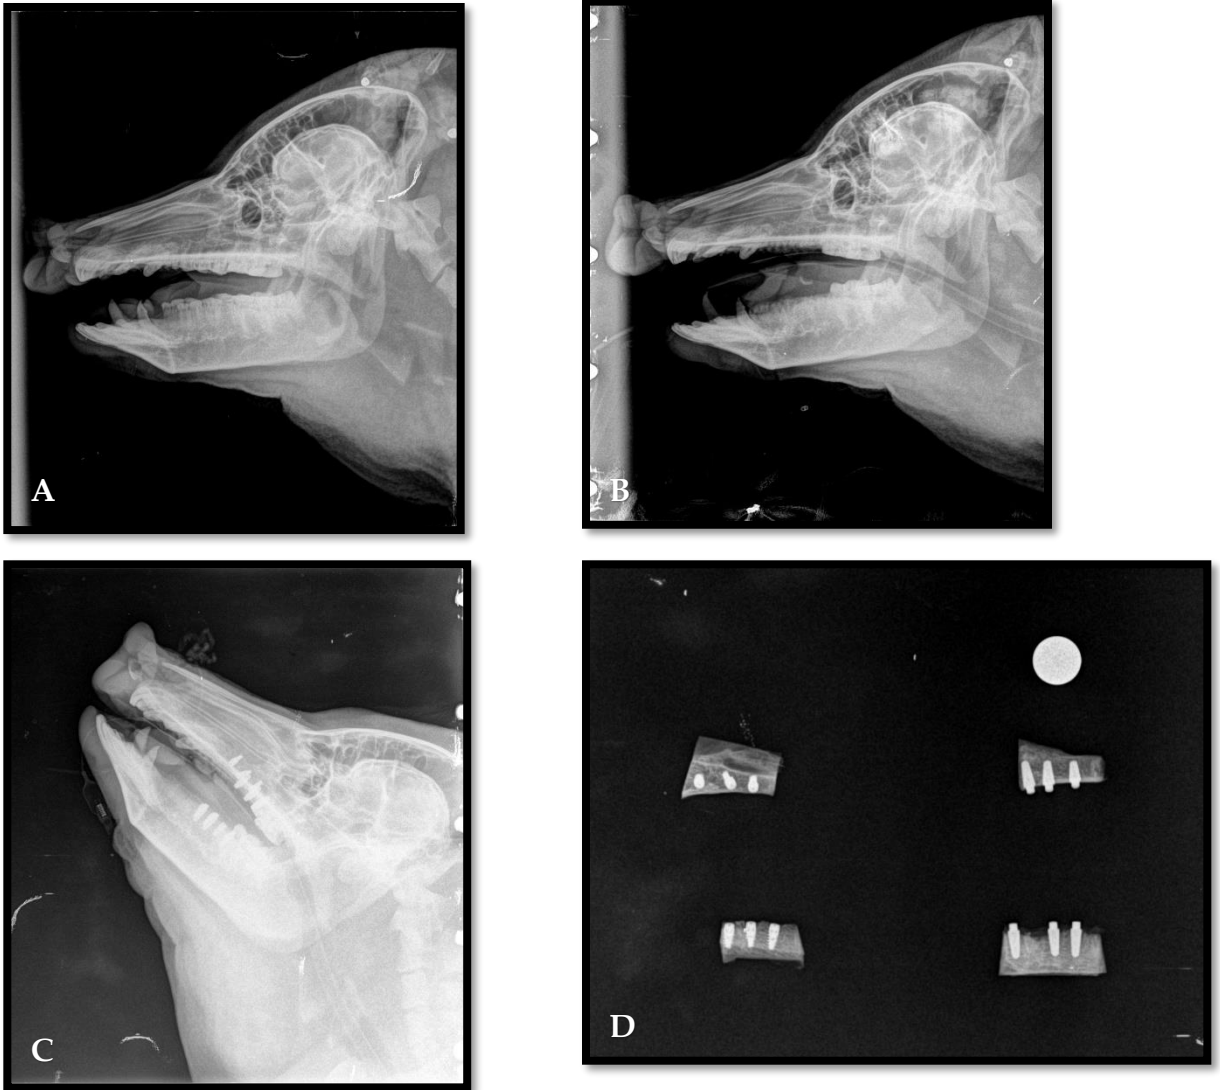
Radiographical assessment of the Minipig.
